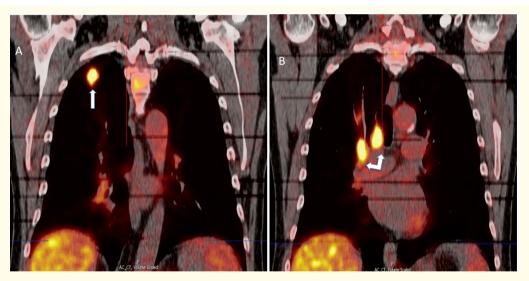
Coronal view from the patient #1 PET/CT at presentation. Panel A shows high FDG avidity (arrow) of the spiculated right upper lobe lung nodule, evidenced by the bright yellow color. Panel B shows high FDG uptake (double arrow) from the mediastinal and hilar lymphadenopathy.
